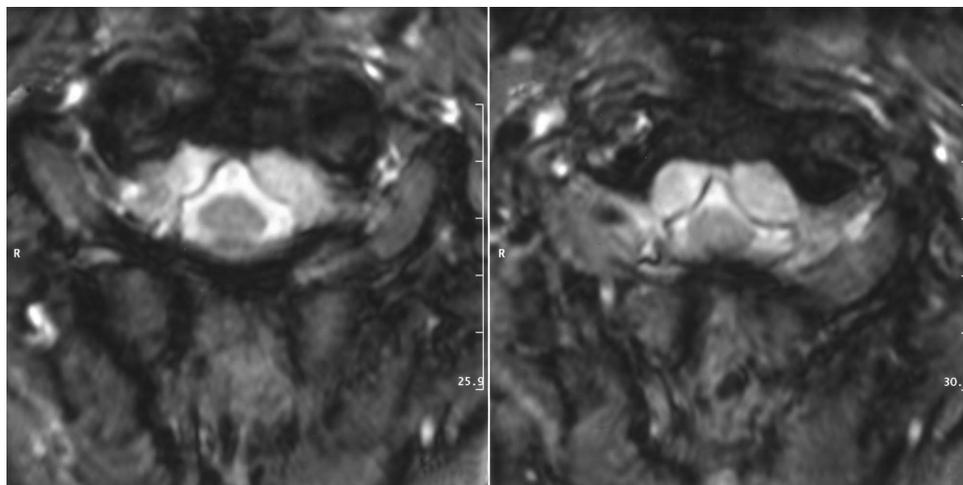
Bilateral intradural extramedullary masses at C2 level on T2-weighted axial MRI.
